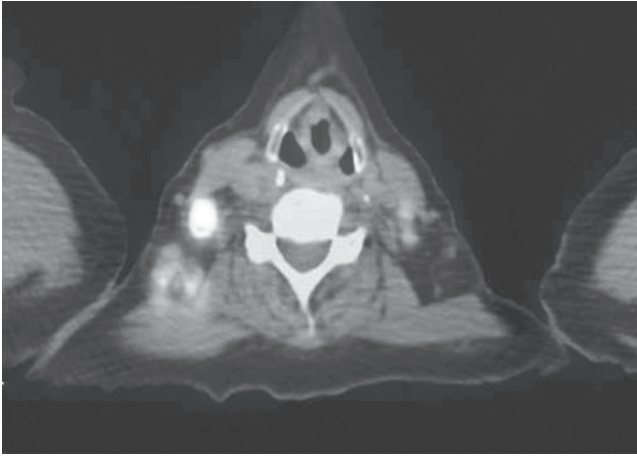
^{18}F -FDG PET/CT. Axial view of the neck demonstrates increased uptake (orange) of ^{18}F -FDG in lymph nodes signifying involvement by lymphoma. For color details, please see color plate section.
